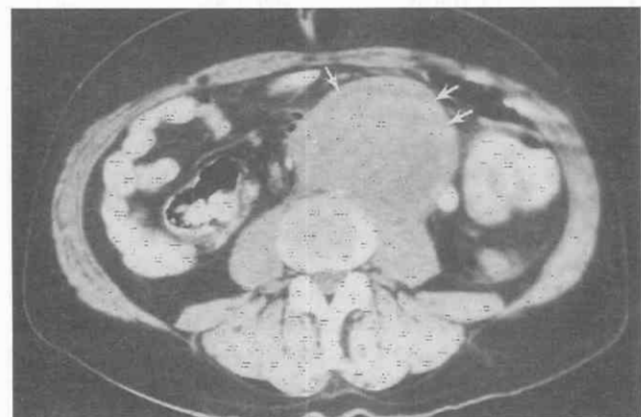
Perianeurysmal fibrosis. Unenhanced CT scan shows a rind of soft tissue (arrows) surrounding the anterior and lateral aspects of a large abdominal aortic aneurysm.
